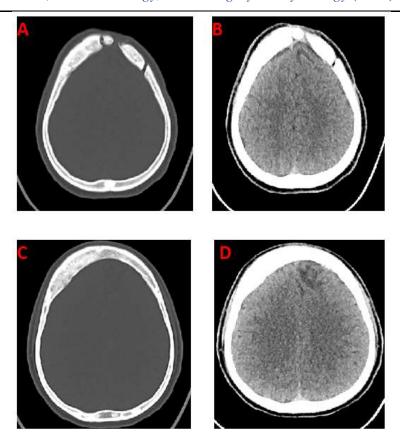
Computed Tomography (CT) showing: Gliotic changes in the left frontal region one year after the initial surgery
